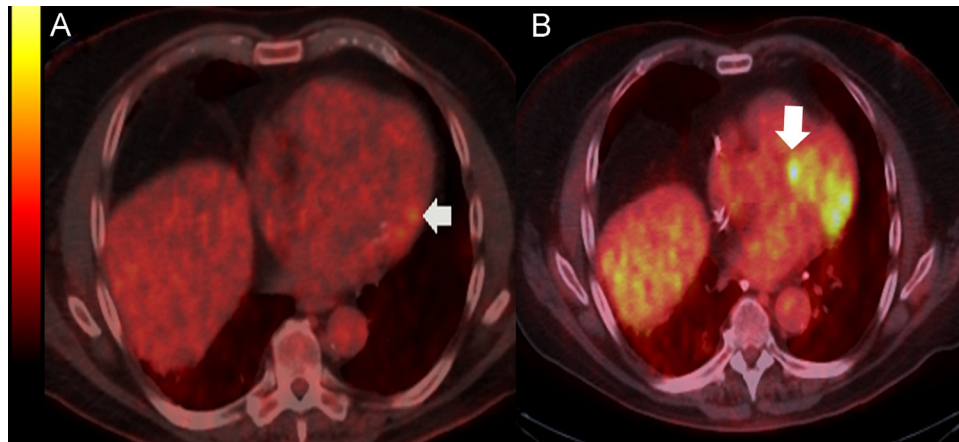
Fasting 18-fluorodeoxyglucose (FDG) positron emission tomography at baseline (A) showing increased uptake, most pronounced in the basal inferolateral area of the myocardium (arrow), consistent with active cardiac sarcoid, and at follow-up (B), showing increased disease progress with FDG uptake in the basal to mid segments of the anterolateral and basal lateral wall segments as well as new FDG uptake in the basal anteroseptal region.
